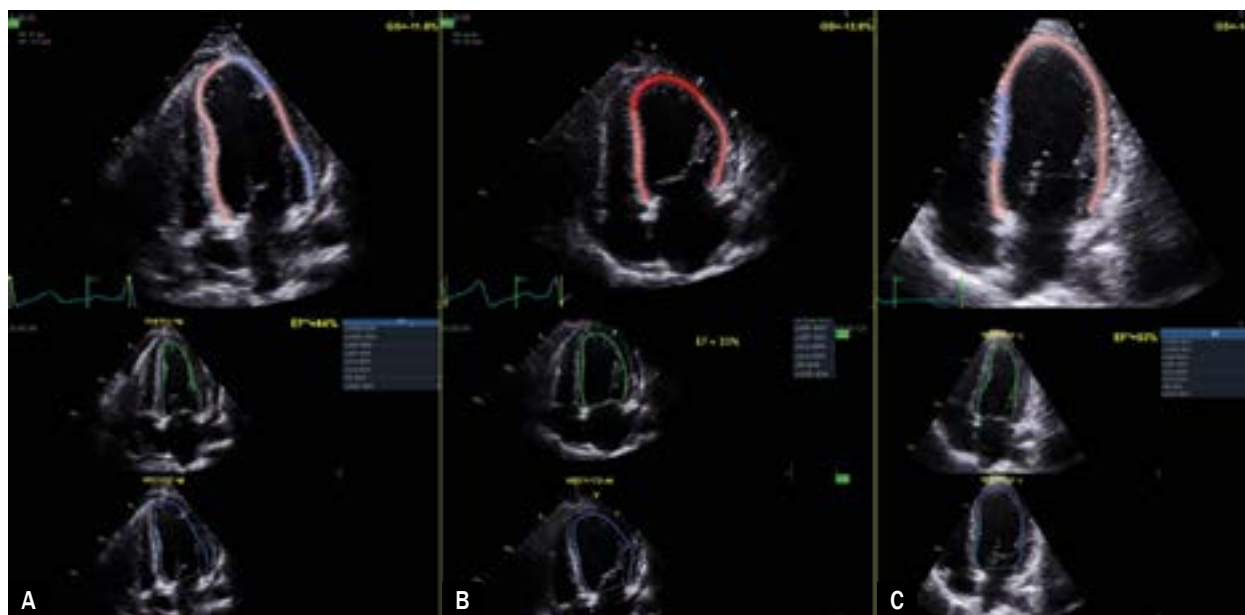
Echocardiography images: A. Initial stage: reduced GLS, mildly reduced EF; B. Decompensation: decreased GLS, decreased EF, more spherical LV; C. Improvement: improved GLS and EF, LV reverse remodeling; EF – ejection fraction; GLS – global longitudinal strain; LV – left ventricle
